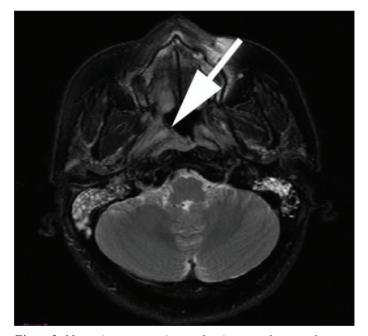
Magnetic resonance image showing nasopharyngeal mass (arrow) and bilateral osteomastoiditis.
